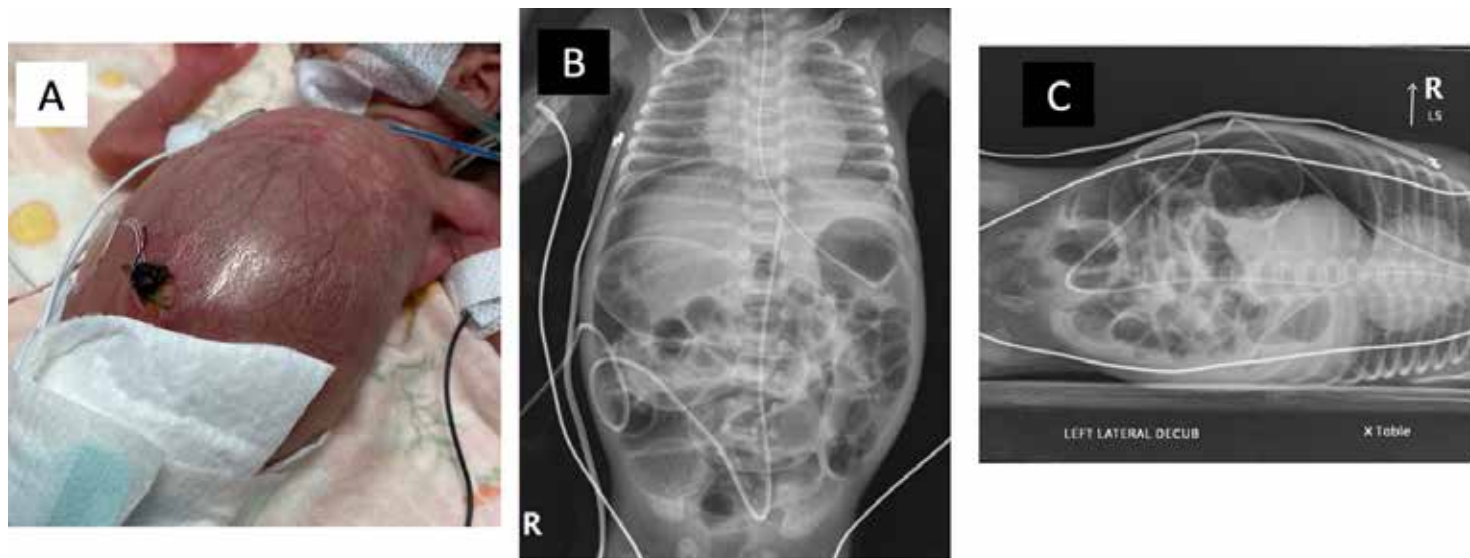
Common physical and radiographic findings in NEC
